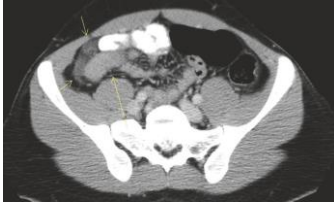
Axial abdominal computed tomography scan depicting thickening around the terminal ileum and colon (yellow arrows) along with extraluminal fluid and reactive lymph nodes.
